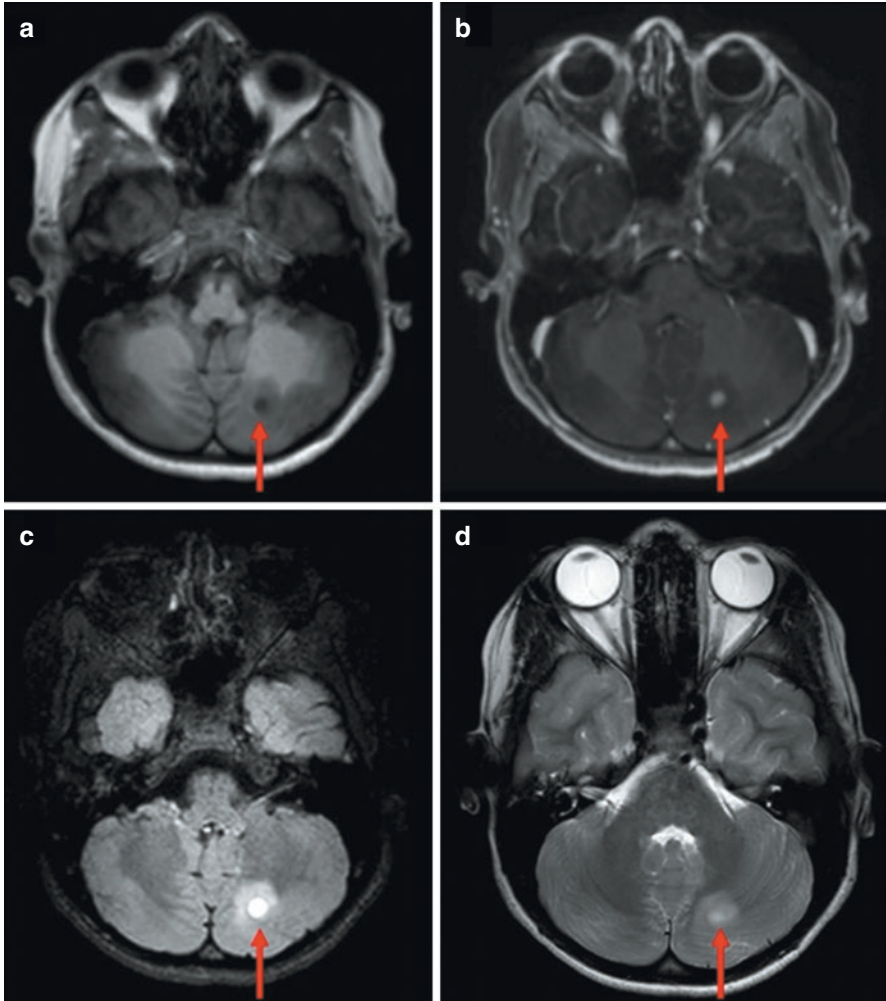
(a)–(d) Diffuse astrocytoma (red arrow): (a) axial T1-weighted; (b) axial T1-weighted post-gadolinium; (c) axial MRI FLAIR; (d) T2-weighted MRI
